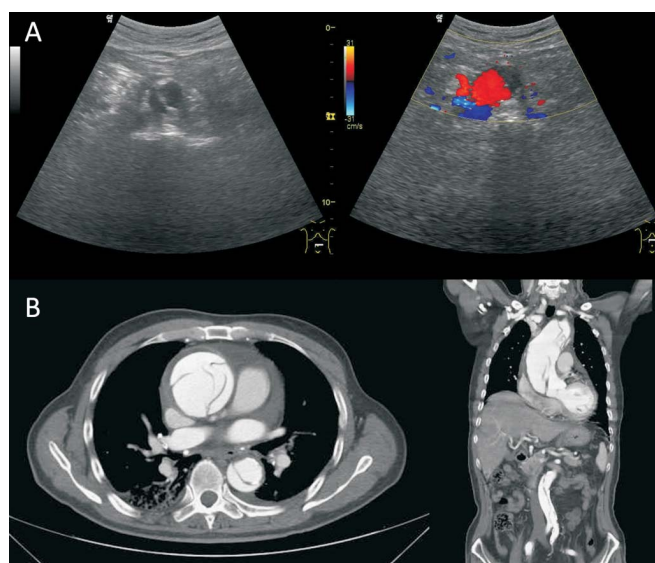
Abdominal ultrasound demonstrated an intimal flap within the abdominal aorta (Left, Panel A). An intimal flap of the abdominal aorta with true (color) and false (no flow) lumens were detected on color Doppler (Right, Panel A). Axial computed tomographic scan depicted a type A aortic dissection with involvement of the aortic valve and ascending thoracic aorta (Left, Panel B). Coronal computed tomographic scan depicted a type A aortic dissection with involvement of the aortic valve, thoracoabdominal aorta and right iliac artery (Right, Panel B).
